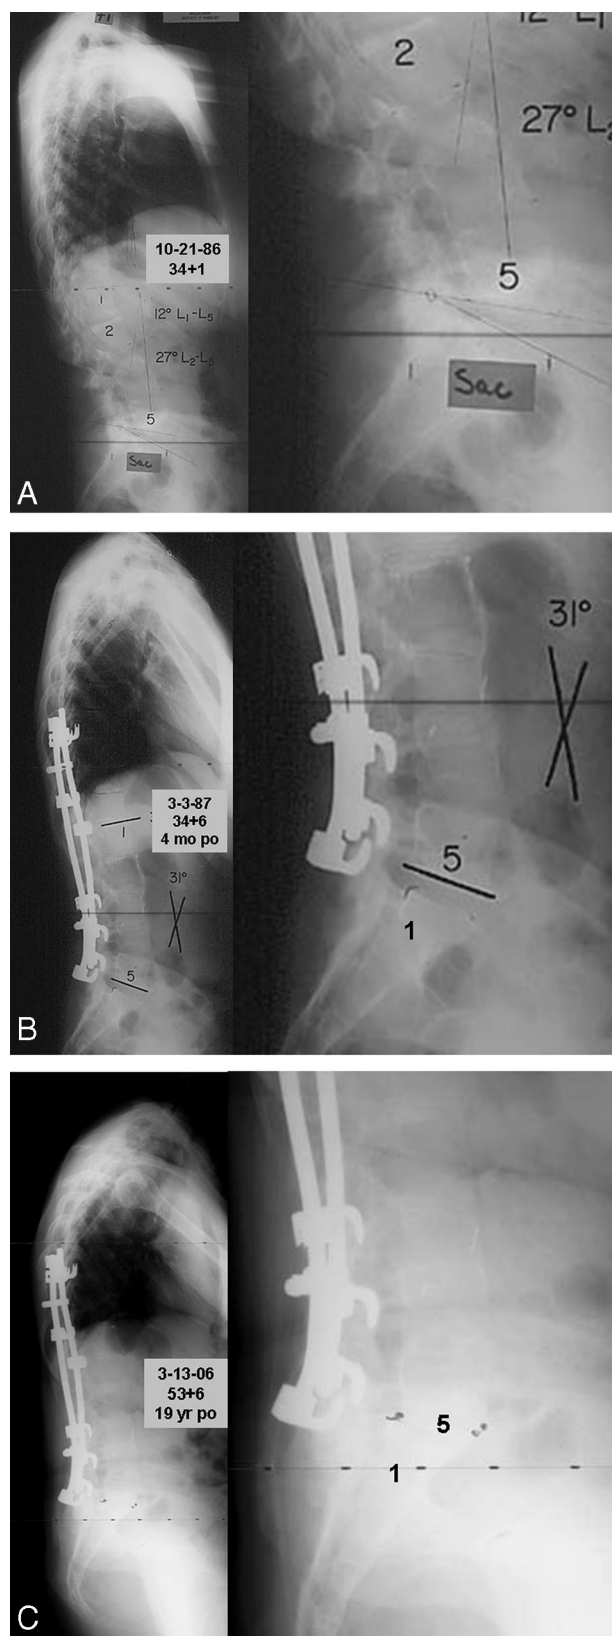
Case of SAD at long-term follow-up. A, Standing long cassette sagittal radiograph preoperative with cone down on L5-S1. B, Standing long cassette sagittal radiograph at 4 months postoperative with cone down on L5-S1. C, Standing long cassette sagittal radiograph at 19 years postoperative with cone down on L5-S1.
